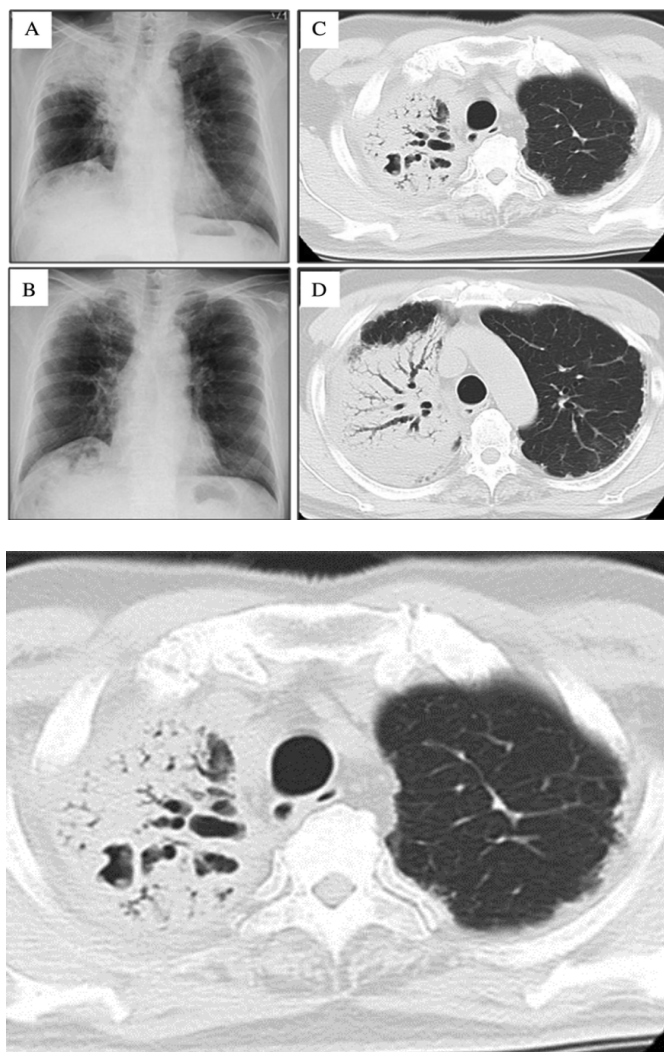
Lobar pneumonia, chest radiography, and lung computed tomography findings (air bronchograms)
